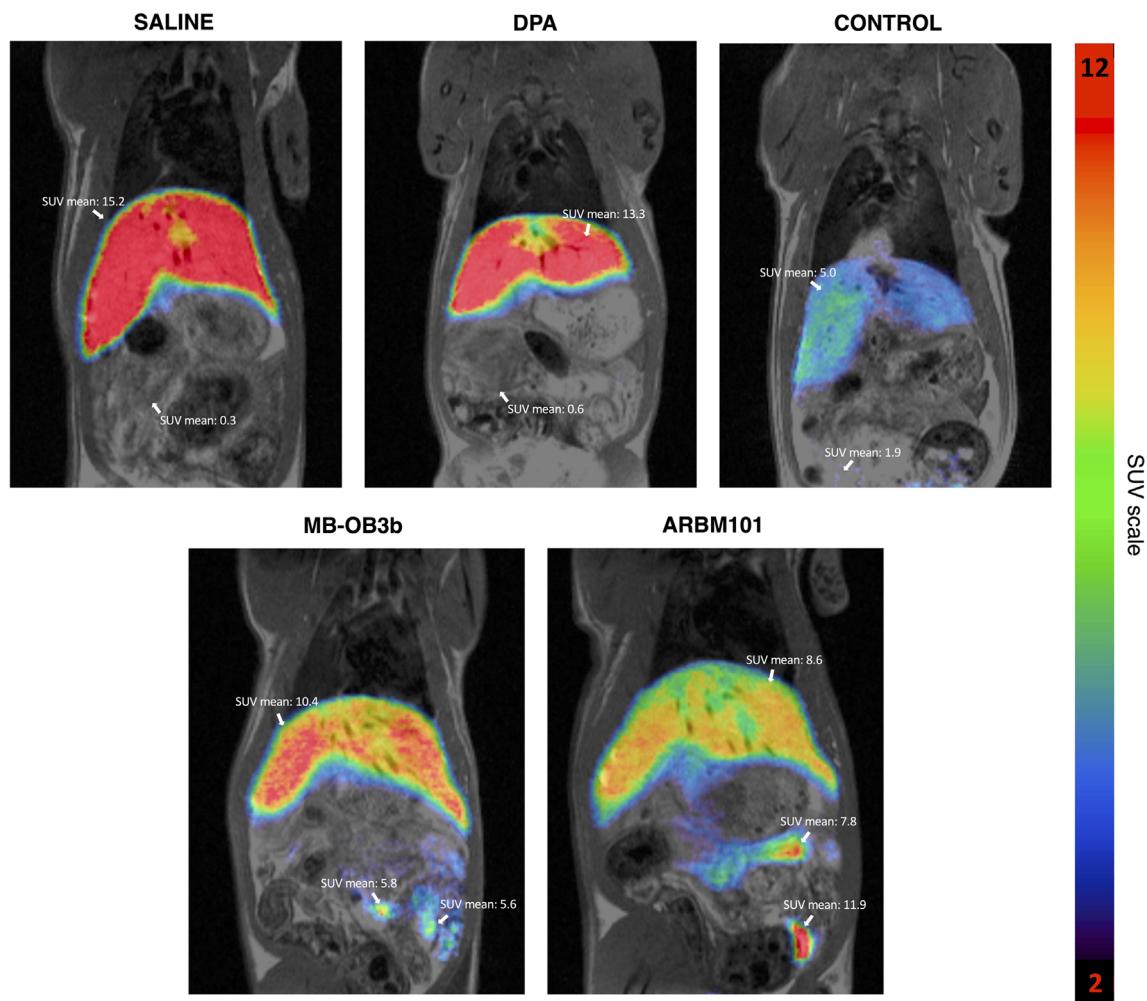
First post-intervention PET/MRI scans (accumulated activity 90 min post-intervention displayed as standard uptake value).
